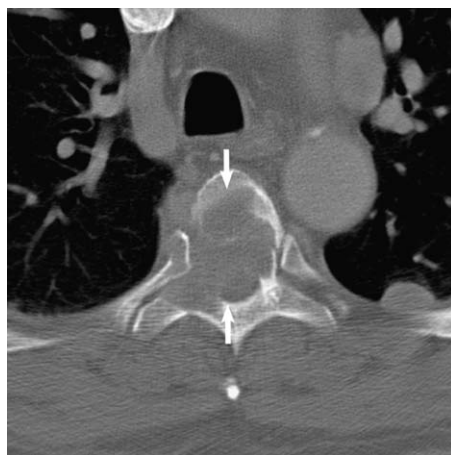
Axial bone algorithm CT (same patient as in Fig. 1) of the T5 vertebra shows characteristic malignant features, including lytic destruction of the medullary cavity and all three spinal columns, a focal paraspinous soft tissue mass, and epidural extension into the central canal.
